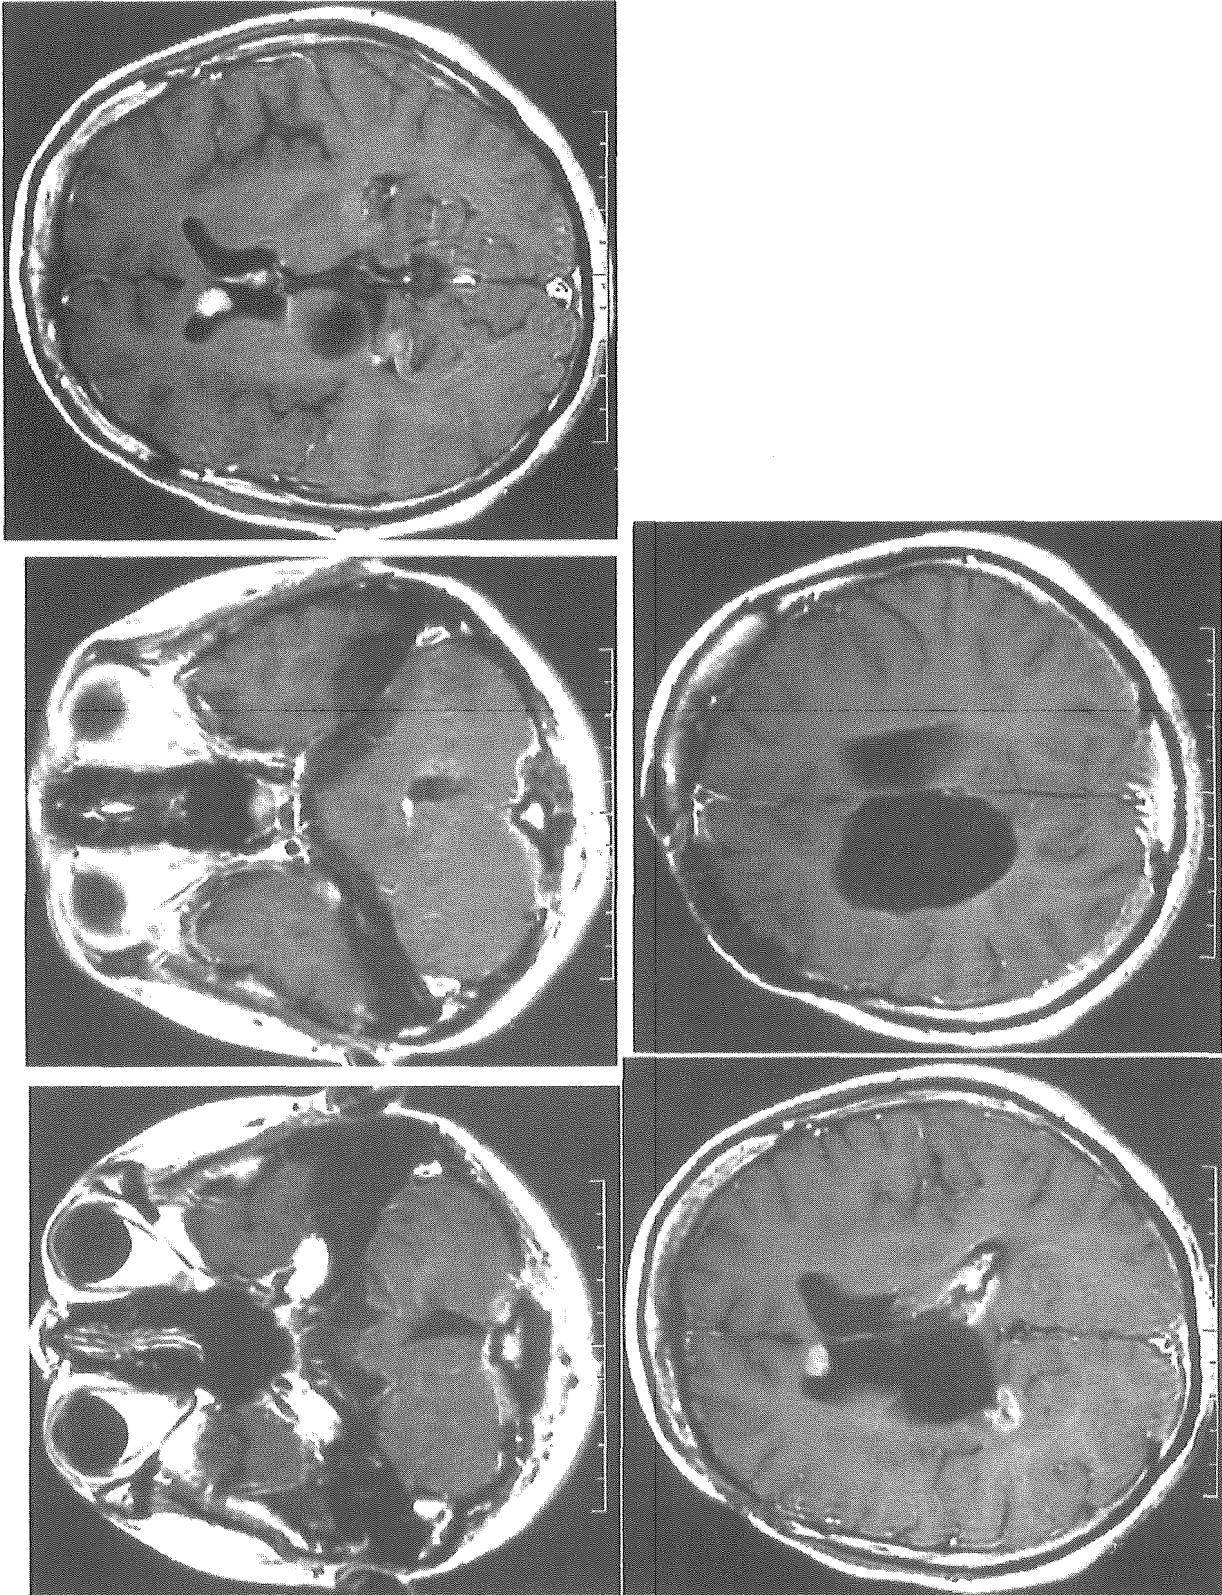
Case 1: Last follow-up axial T1-weighted MR images with gadolinium-diethylenetriaminepenta-acetic acid performed 9 years and 10 months after the initial treatment showing good control of the primary tumour and multiple nodular disseminations treated by Gamma knife radiosurgery, but new dissemination in the anterior horn of the right lateral ventricle
